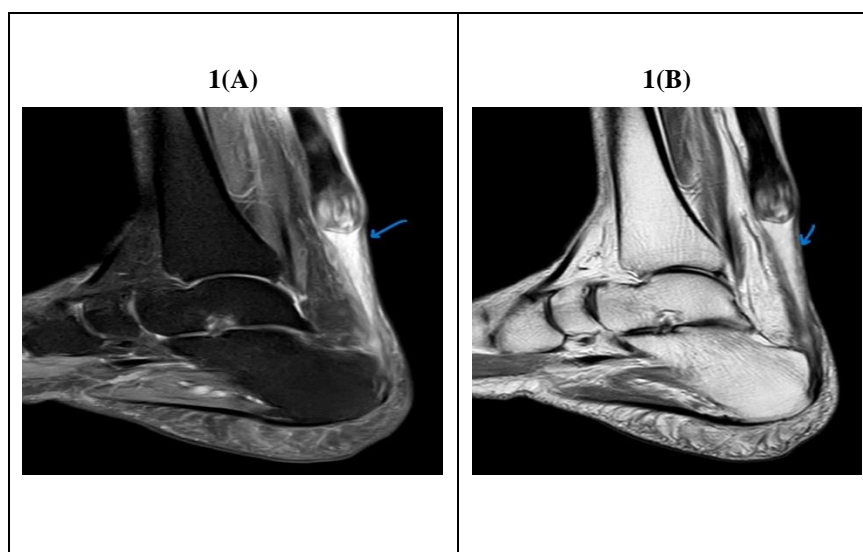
(a), 1 (b) show MRI of the right ankle in a 50 years old male patient who presented with difficulty in walking and a prior history of trauma. The Sagittal Proton density (a) and Sagittal T2 weighted (b) images of right ankle reveal central dehiscence of Achilles tendon (blue arrow) with retraction of central portion of the tendon and intact concentric peripheral fibers indicating a partial rupture of Achilles tendon.
